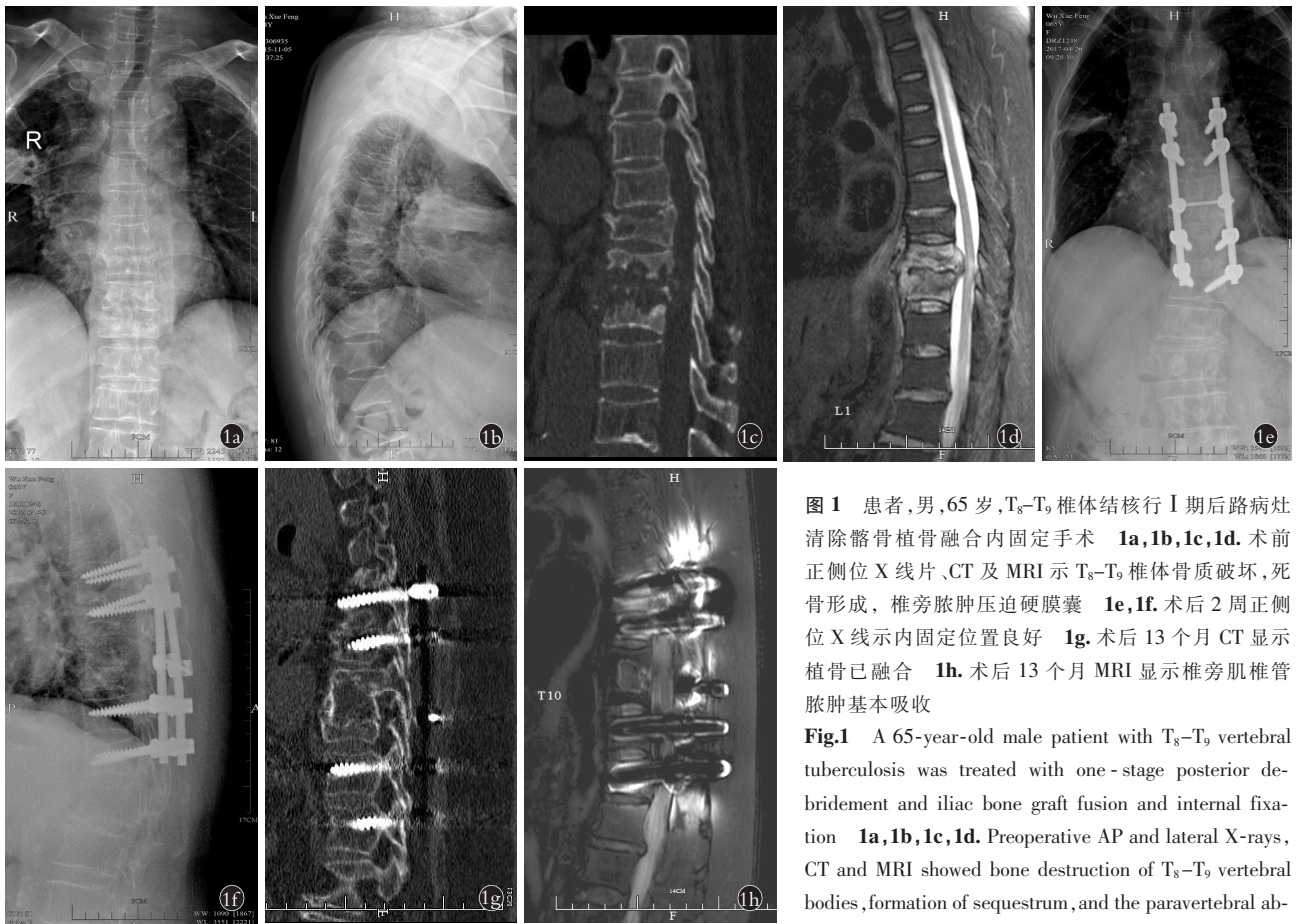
患者,男,65岁,T₈-T₉椎体结核行 I 期后路病灶清除髂骨植骨融合内固定手术 1a,1b,1c,1d。术前正侧位 X 线片、CT 及 MRI 示 T₈-T₉椎体骨质破坏,死骨形成,椎旁脓肿压迫硬膜囊 1e,1f。术后 2 周正侧位 X 线示内固定位置良好 1g。术后 13 个月 CT 显示植骨已融合 1h。术后 13 个月 MRI 显示椎旁肌椎管脓肿基本吸收
